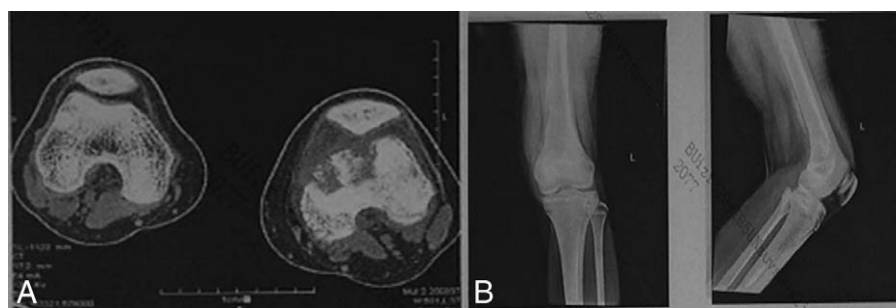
Computed tomography and radiographic examination of the left femur showed bone destruction, suggesting that a malignant tumor was present.
